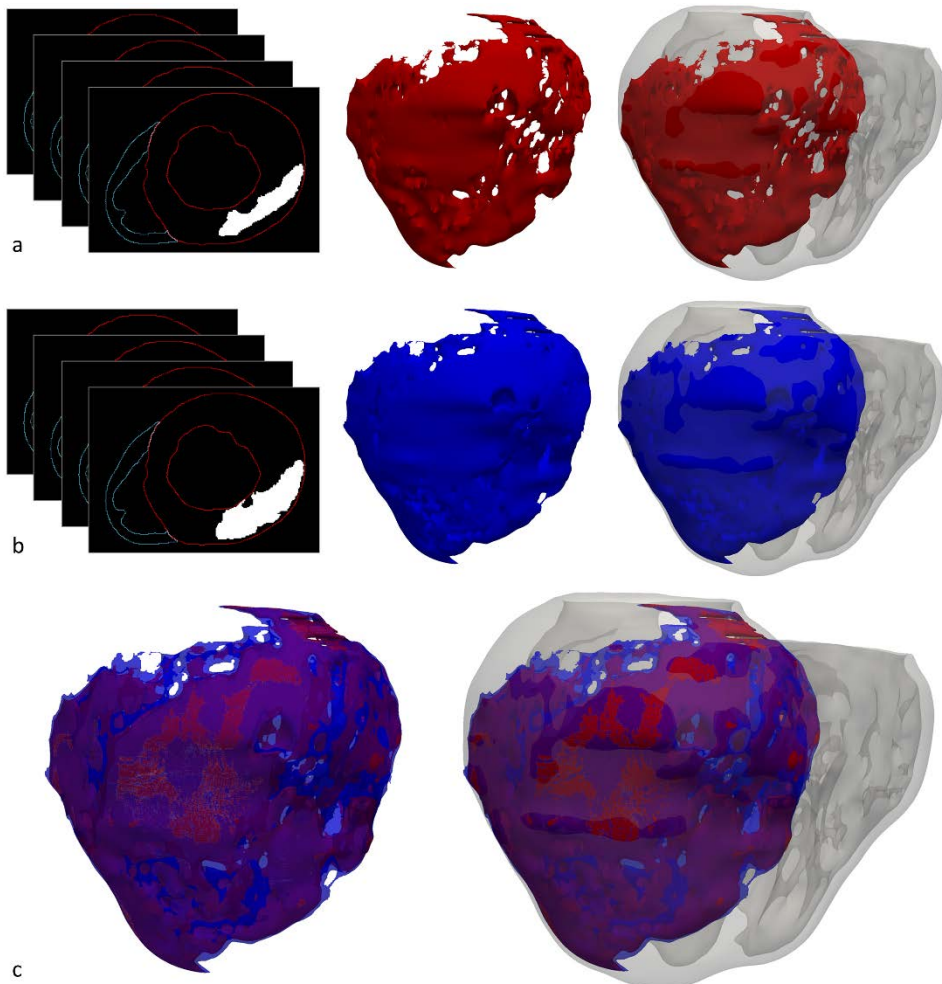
3D representation of the heterogeneous remodelling associated with the MI reconstructed from DE-MRI images, including infarct scar and BZ. Top row (*a*) displays the 3D surface corresponding to the infarct scar (*red*), while the surface in the middle row (*b*) represents the whole ischaemic injury (*blue*), enclosing both the scar and the BZ. Both rows (*a* and *b*) show a representation of the volumetric binary masks created by the segmentation process (*left column*) and posterior views of the refined version of the 3D surfaces generated from those binary masks, both alone (*middle column*) and displayed into the 3D surface model of ventricles rendered with transparency (*right column*). Bottom row (*c*) shows the overlap of both 3D surfaces, representing the infarct scar (*red*) and the entire MI (*transparent blue*), respectively. The space enclosed by the whole MI surface and not covered by the infarct scar surface corresponds to the BZ, which surrounds the scar as can be appreciated.
